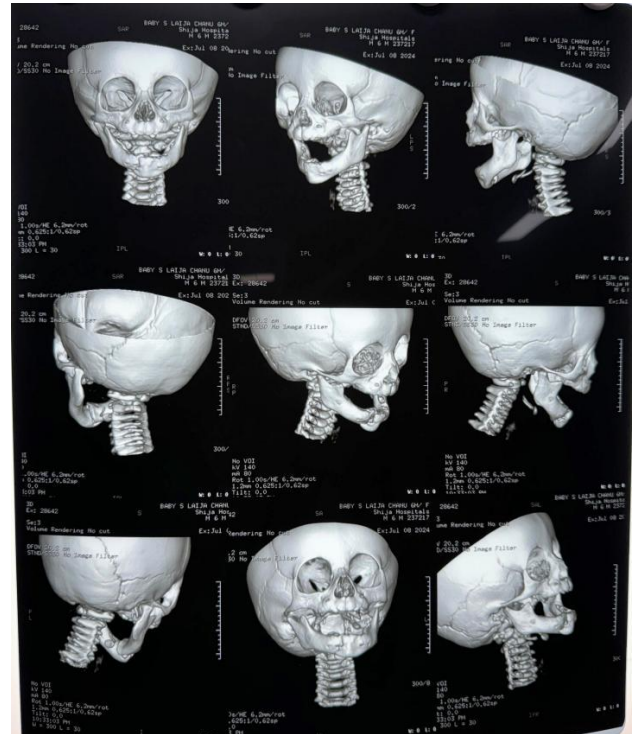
Pre op 3d CT mid face.
